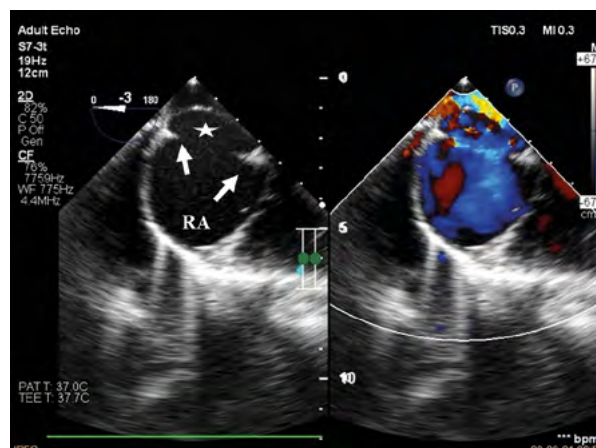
Transoesophageal echocardiography. Large intra-atrial defect (2 cm) of the ostium secundum type (arrows). Enlarged right atrium (RA). In the left atrium additional septum and free space. No thrombus between 2 layers (asterisk). In the color Doppler, undisturbed blood flow between the atria
